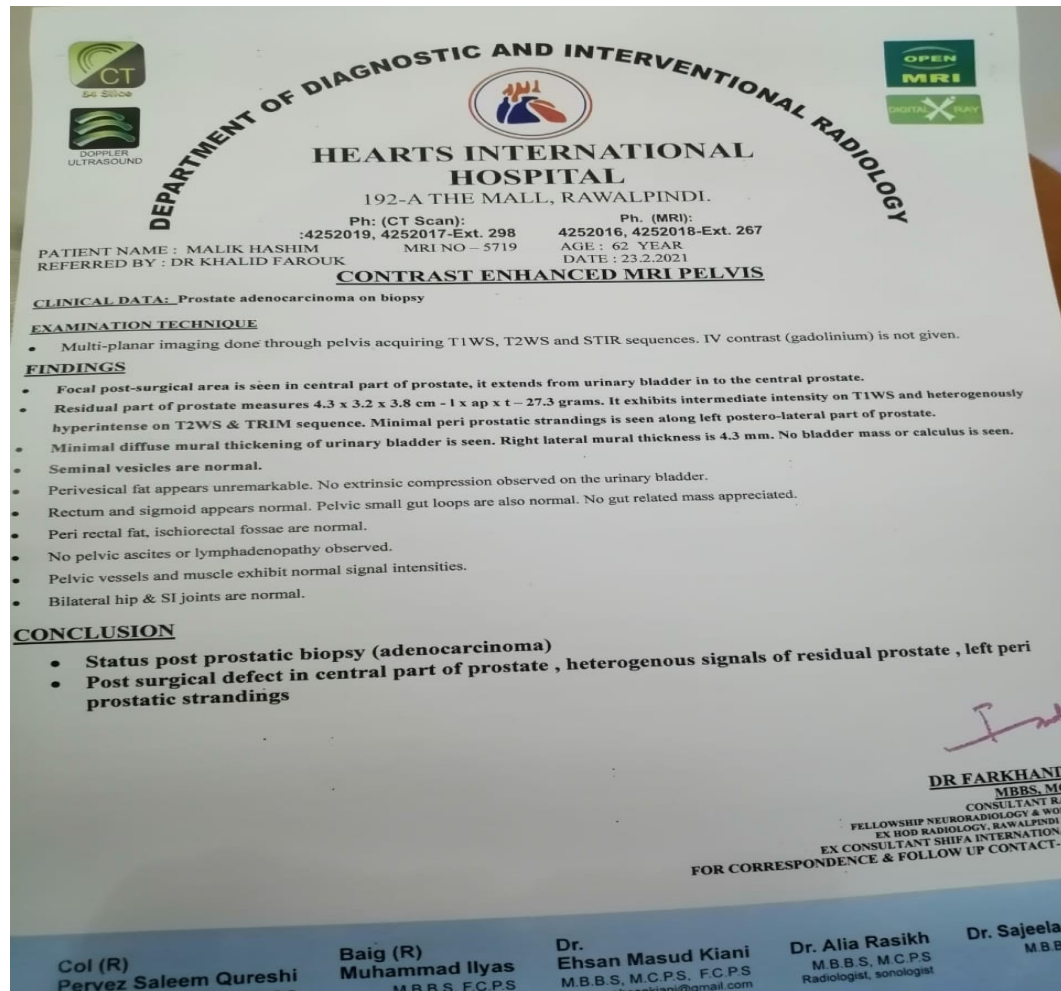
MRI Reports of Bladder Cancer Patients
